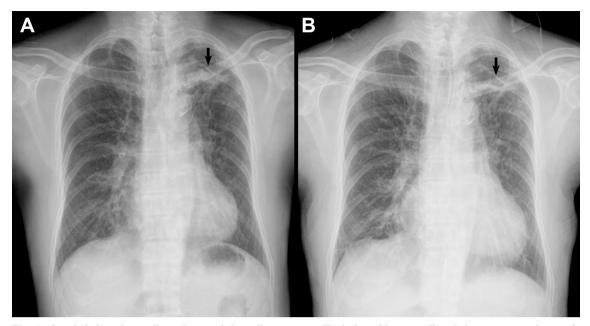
On admission, chest radiography revealed a radiopaque mass-like lesion with surrounding air lucency, suggesting an air crescent sign (black arrow), and some fibrocalcified nodules located at the left upper lobe (A). Seven days after admission, the previous intracavitary mass at the left upper lobe disappeared with only a residual fibrotic scar and thin wall cavity (black arrow) (B).
